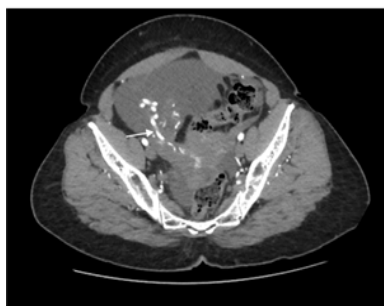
Arterial phase CT axial image demonstrating the vascular supply of the lesion (White arrow) arising from right gonadal artery.
